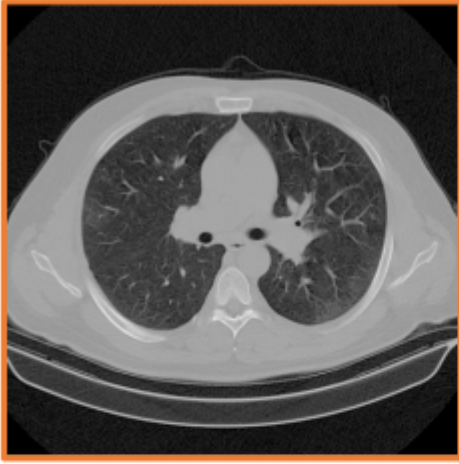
This figure show some of the first, middle, and last images of CT scans sequence.
